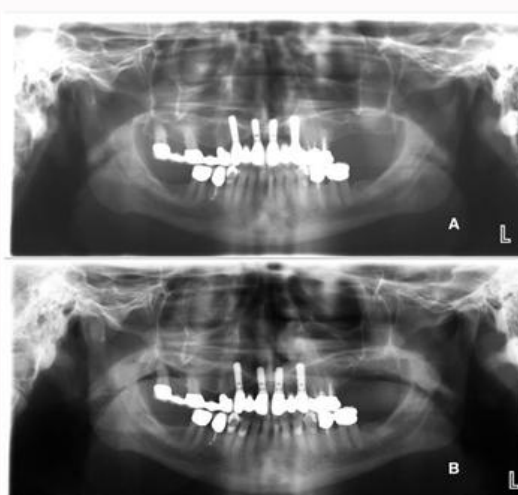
Radiographic exam after (A) 3 and (B) 5 years of follow-up, showing maintenance of bone level.
